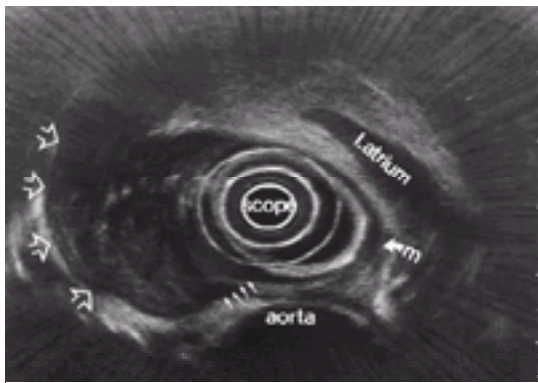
Endoscopic ultrasonographic image of a mass in the mid-esophagus; note the adjacent structures in the mediastinum, aorta, and the left atrium. The wall structure of the esophagus is also evident; the thickest hypoechoic layer is the muscularis propria (m). The tumor has extended beyond the muscularis (small arrows) and into the mediastinum (large arrows).
